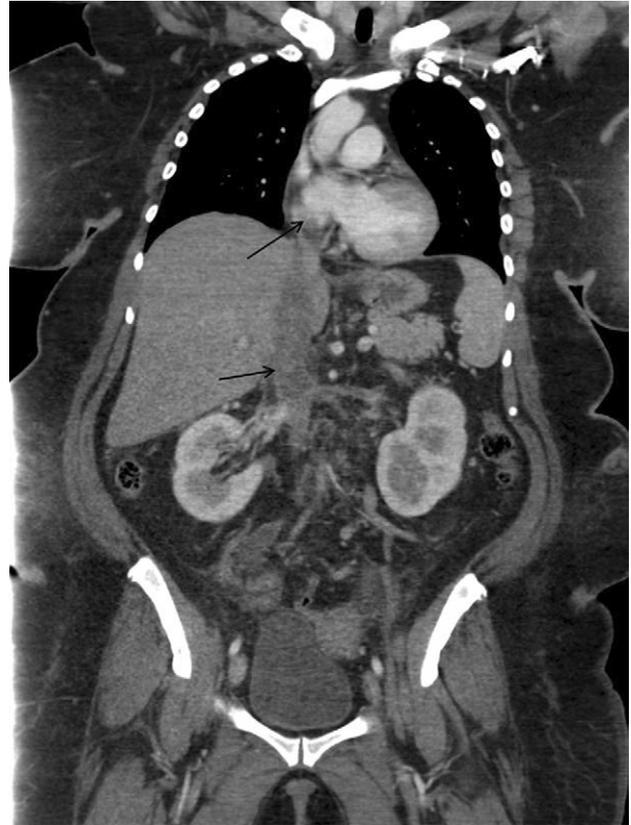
A coronal view computed tomography scan of the chest and abdomen shows the thrombus of the inferior vena cava extending to the right atrium (arrows).
